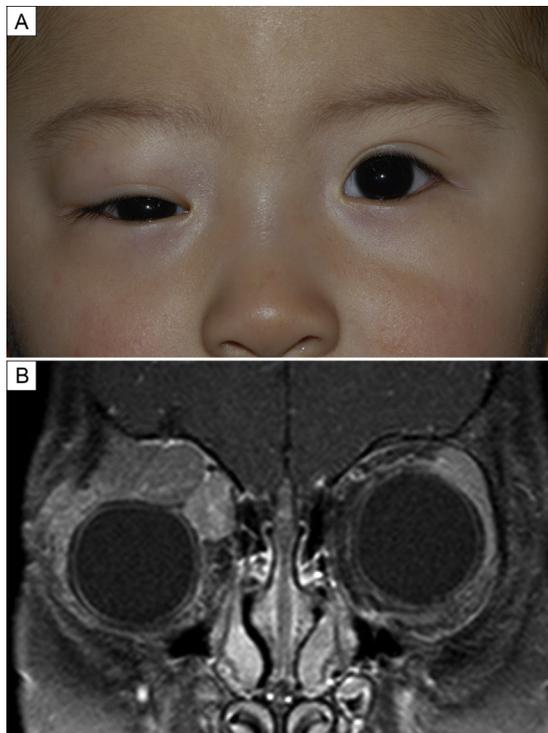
A, Clinical image at presentation demonstrating right proptosis, superior orbital fullness and hypoglobus. B, Magnetic resonance imaging of the brain and orbits showing a $1.3 \times 2.6 \times 2.1$ cm multilobulated infiltrative right orbital mass, with bony erosion of the lateral orbital wall. The lesion was isointense to muscle on T1-weighted images and demonstrated heterogeneous contrast enhancement.
